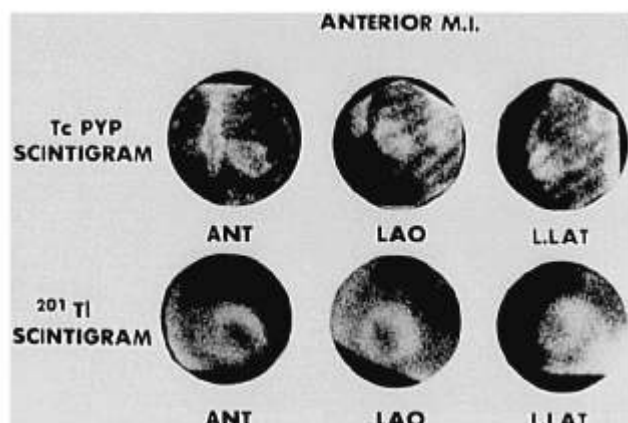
Tc-pyrophosphate infarct imaging. Shown are  $^{99m}\text{Tc}$ -pyrophosphate (TcPYP) (above) and  $\text{Tl}^{201}$  rest scintigrams (below) in anterior (ANT), left anterior oblique (LAO) and left lateral projections (L.LAT). Note the "hot spot" to the left of the sternum and anterior in the chest in the TcPYP images. This "hot spot" represents uptake of TcPYP by an acute anterior myocardial infarction, and corresponds to the "cold spot" or perfusion defect on the Tl-201 images. While these findings are consistent with infarction and are extremely sensitive to acute infarction, they are not specific, and may be seen with severe ischemia. (Reproduced from Botvinick EH, Shames DM: Nuclear Cardiology—Clinical Applications. Baltimore, Williams and Wilkins, 1979, with permission).
